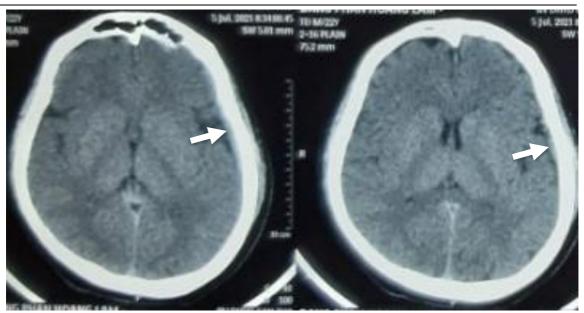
The left subdural hematoma on the brain CT scan
